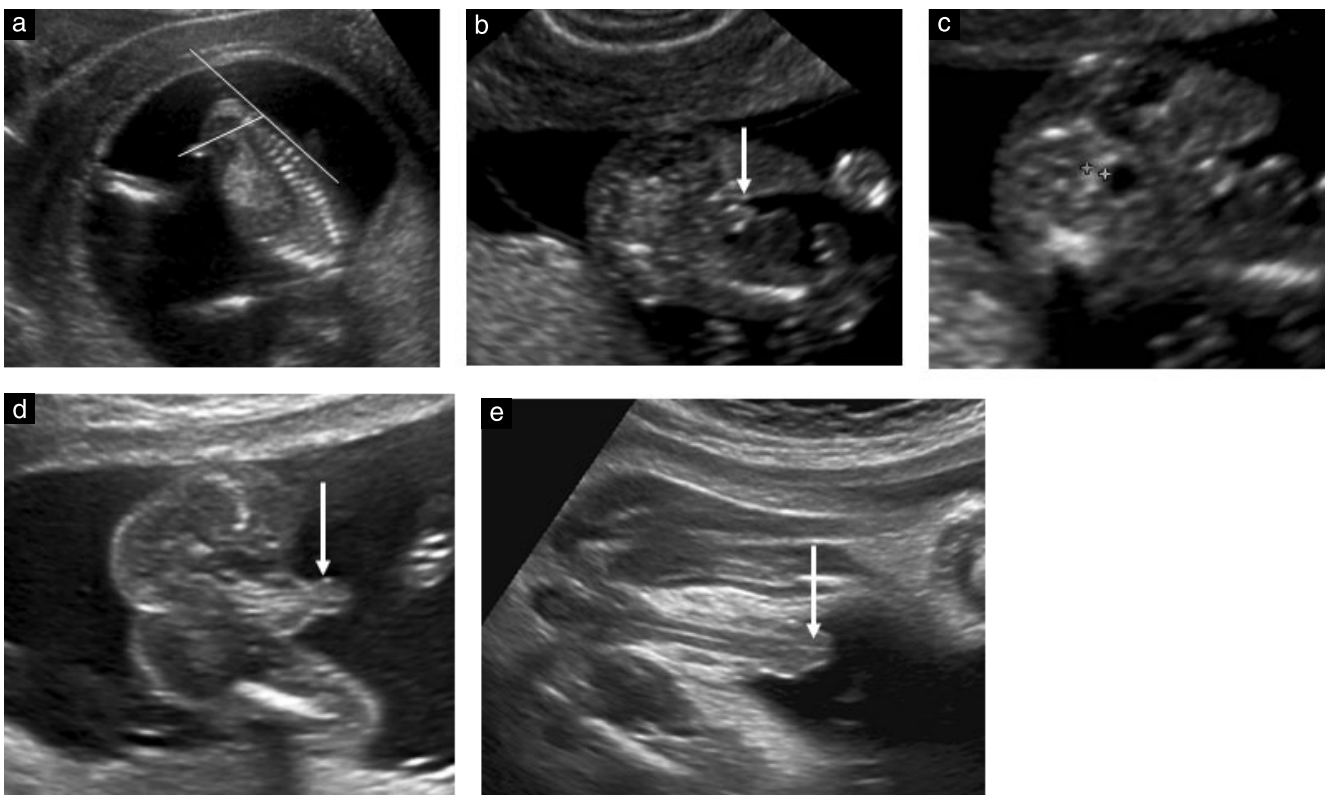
Sagittal (a) and transverse (b–e) ultrasound images showing normal male phenotypic genitalia: (a) at 12.8 weeks, showing anterior-directed genital tubercle, with an angle to a horizontal line through the lumbosacral skin surface of $> 30^\circ$; (b,c) at 14.4 weeks, showing penile shaft (arrow) (b) and internal genitalia with bladder–rectum distance of 1.4 mm (calipers) and concave interface with bladder consistent with male gender (c); (d) at 19 weeks, showing penile shaft and dome-shaped scrotal sac (arrow); (e) at 32 weeks, showing length of penile shaft, with bulbous appearance of glans penis and urethra visible extending to tip of glans penis as a thin echogenic line (arrow).
